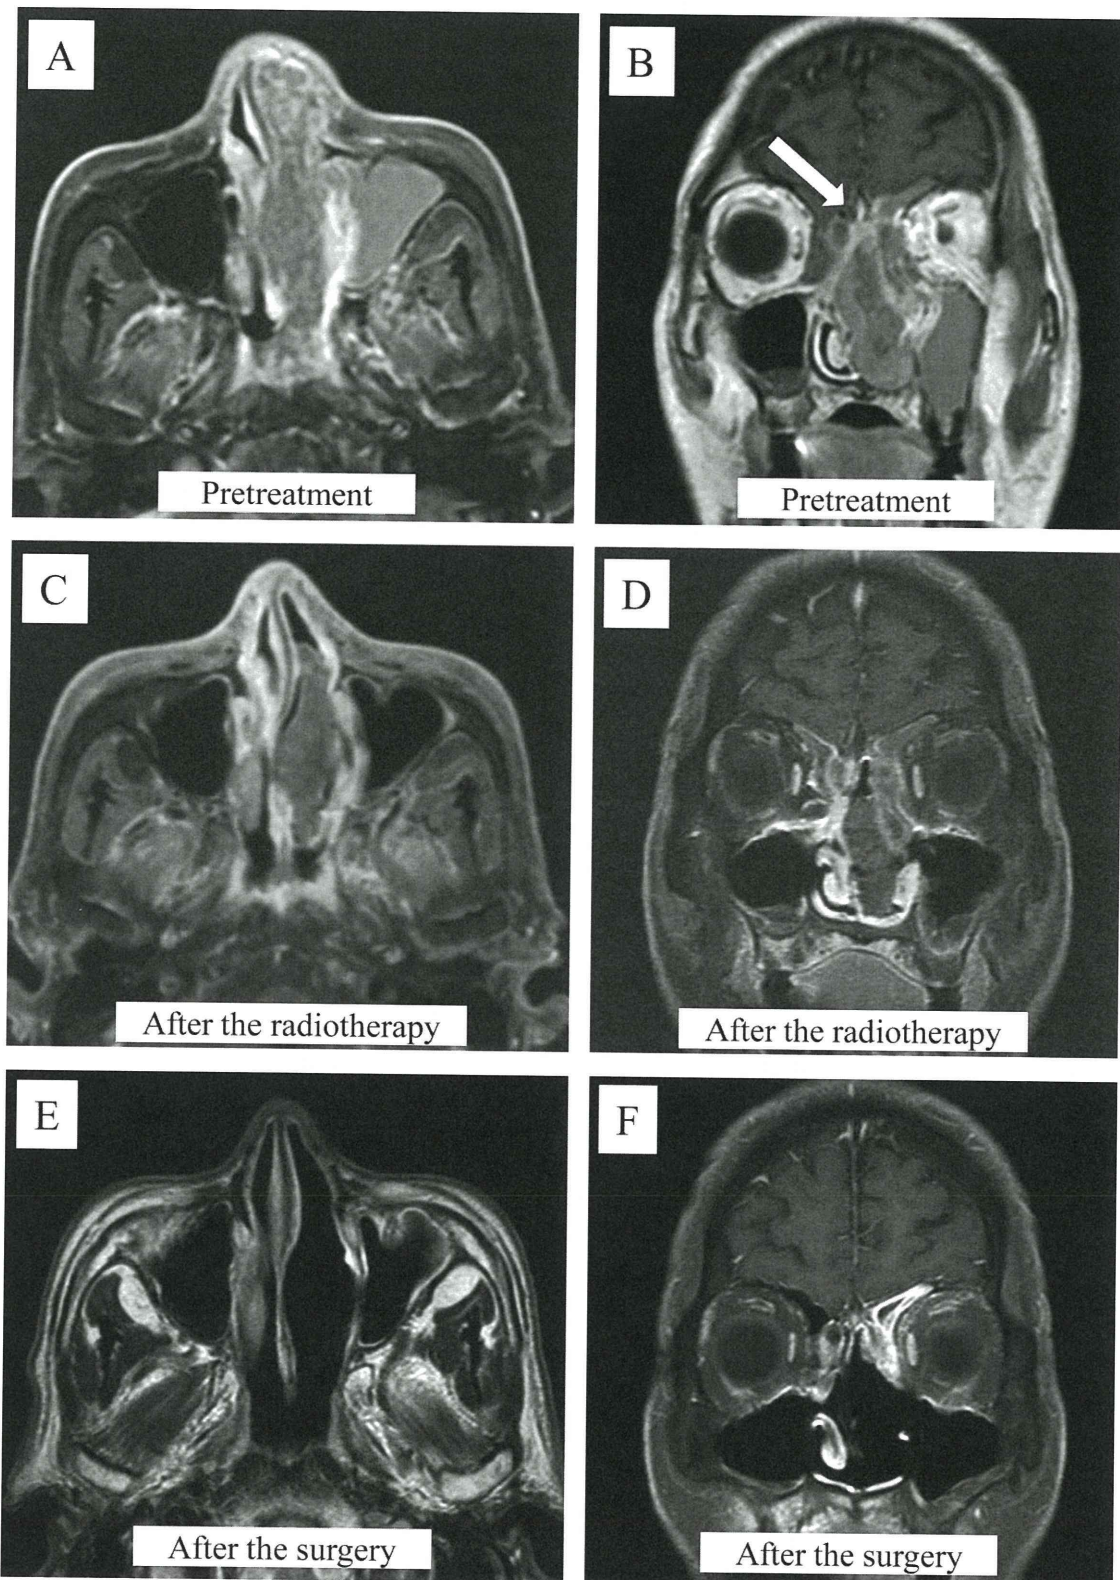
Magnetic resonance imaging (MRI) of the 70-year-old male patient treated with the radiotherapy followed with the surgery. (A) Pretreatment images of the extramedullary plasmacytoma of the head and neck (EMP) located in the nasal cavity extended to the paranasal cavity. (B) A coronal image of MRI showing an invasion of the base of the skull. (C, D) Axial and coronal images of the residual tumor at the concha nasalis media shrunk after the radiotherapy. (E, F) Images of nasal and paranasal cavities after the surgical removal.
